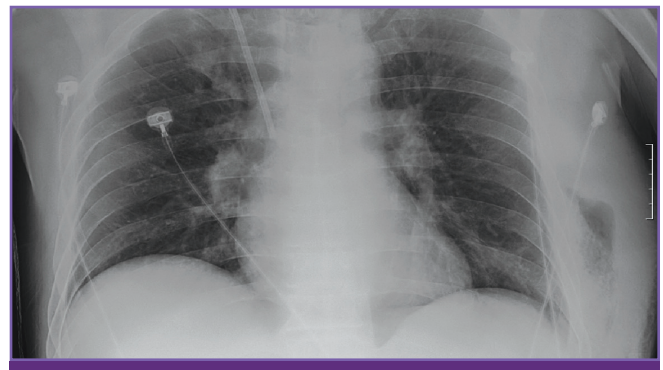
Chest X-ray shows soft tissue swelling on the left chest wall with internal air density.
